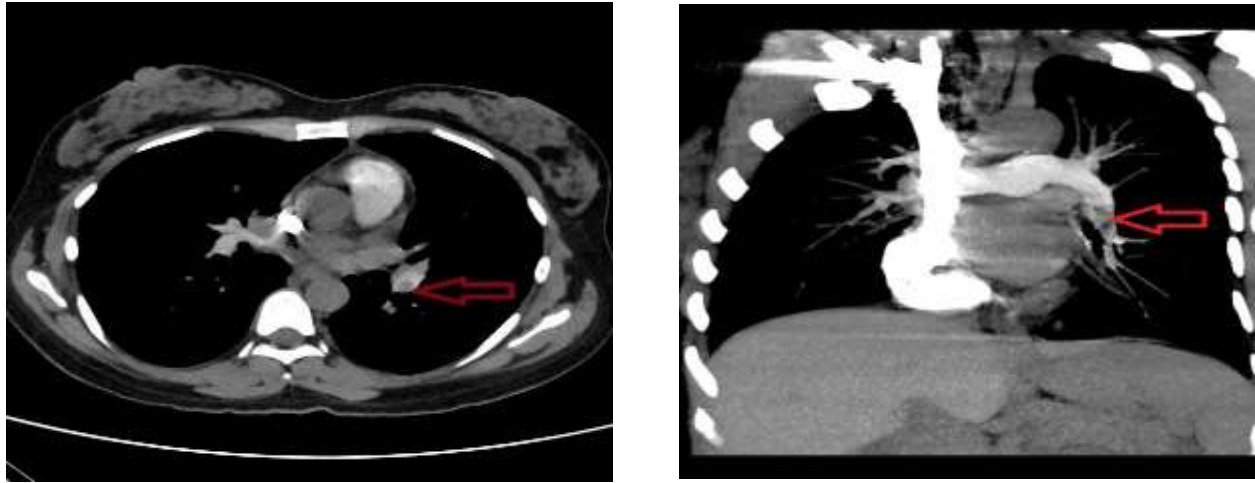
(a) Axial section of computed tomography pulmonary angiogram (CTPA) showing thrombus in left inferior lobar pulmonary artery (arrow). (b) Maximum intensity projection (MIP) image of the coronal section showing filling defect in left inferior pulmonary artery (arrow).
